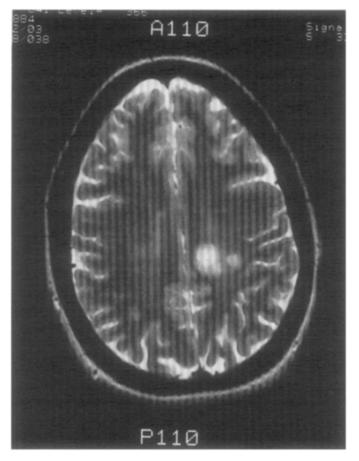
MR image of the cerebrum in a patient with multiple sclerosis demonstrates one large lesion and several smaller lesions in the white matter.
